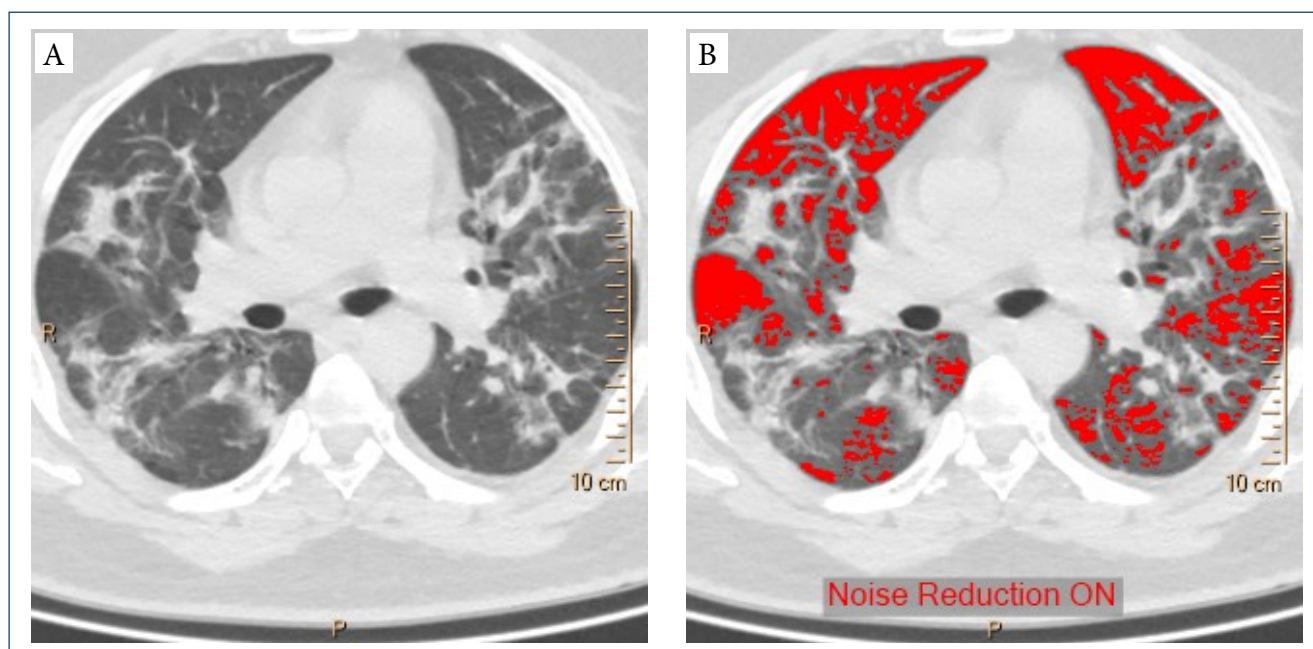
(A) Computed tomography image and (B) density mask with -750 Hounsfield units.
